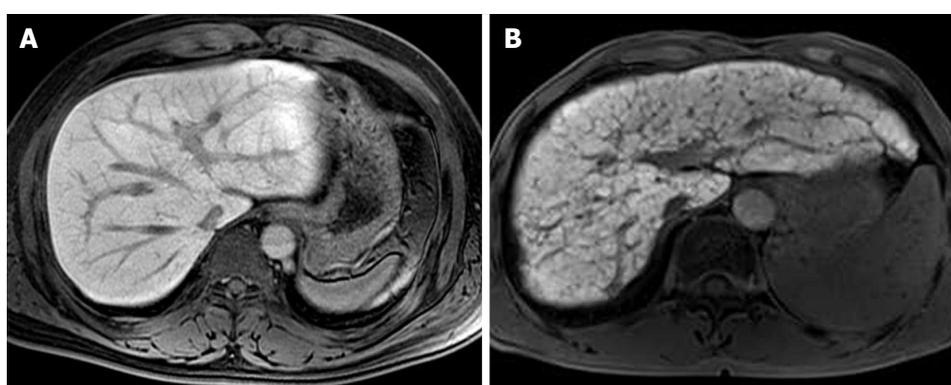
Fat saturated T1-weighted magnetic resonance images of 20-min delay after injection of gadoxetate disodium. A: The image of healthy patient shows homogenous high signal intensity of hepatic parenchyma; B: The image of patient with liver cirrhosis shows heterogeneity of hepatic parenchyma enhancement with hypointense reticulations representing septal fibrosis, and decreased enhancement degree as compared with the image (A).
